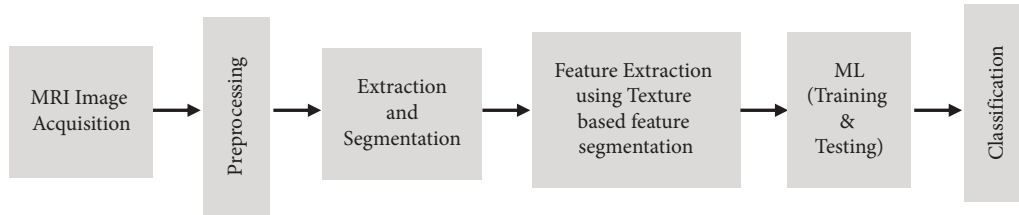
Usable method for brain tumor detection in MRI imaging.
